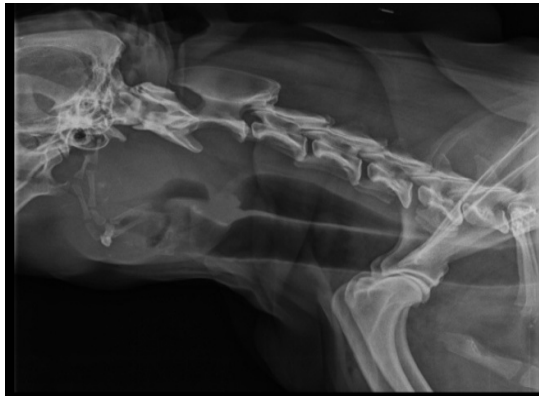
Lateral radiograph of the neck revealed well defined area of soft tissue swelling around larynx
